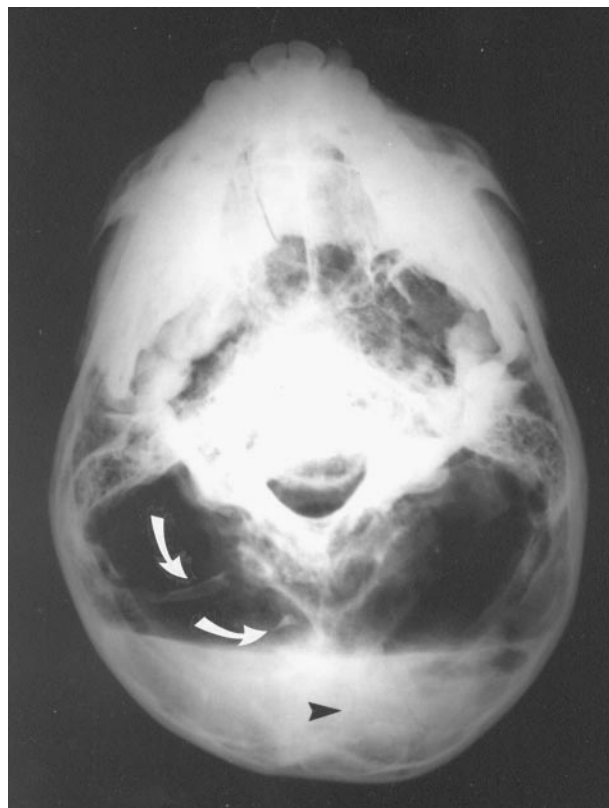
Submental vertex radiograph of Tutankhamen's skull shows the opaque resin layer in the occipital region (arrowhead) and the bone fragments (curved arrows). (Reprinted courtesy of the University of Liverpool.)
